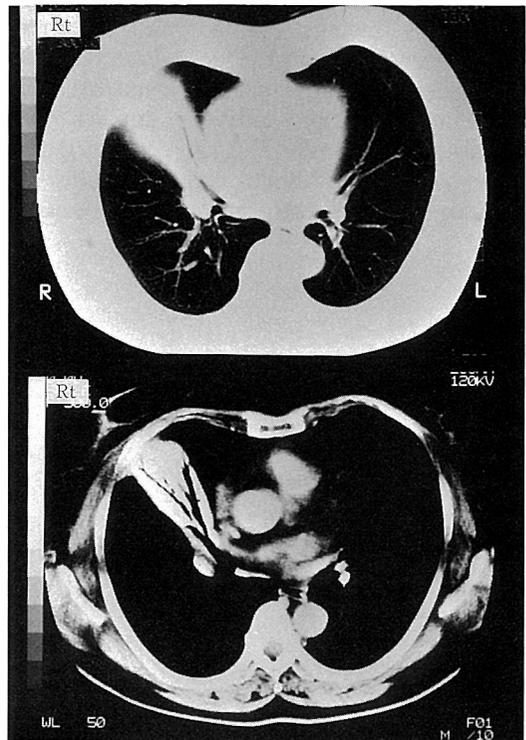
Chest enhance CT revealed the consolidation was homogeneously enhanced except for air bronchogram without appreciable loss of lung volume.
